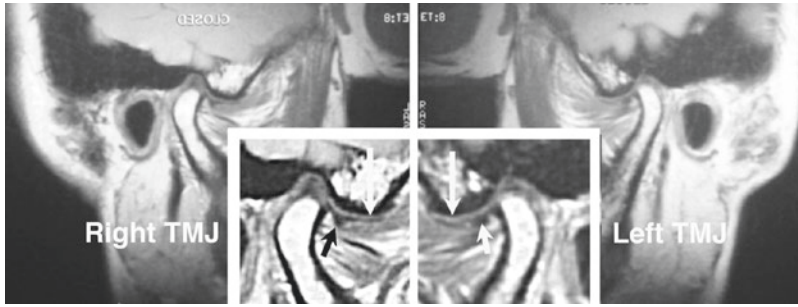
MRI of blepharospasm patient (Case 5) reveals internal derangement of the articular disc in each TMJ. Long white arrows: apex of articular eminence in right and left TMJs. Dark arrow: points to an anteriorly displaced articular disc fragment in right TMJ. Small
